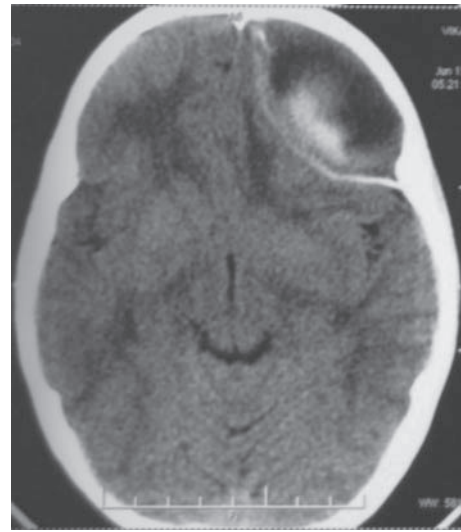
Non contrast axial CT scan of the patient showing a left frontal extraaxial lesion with hyperdense margins and mass effect
